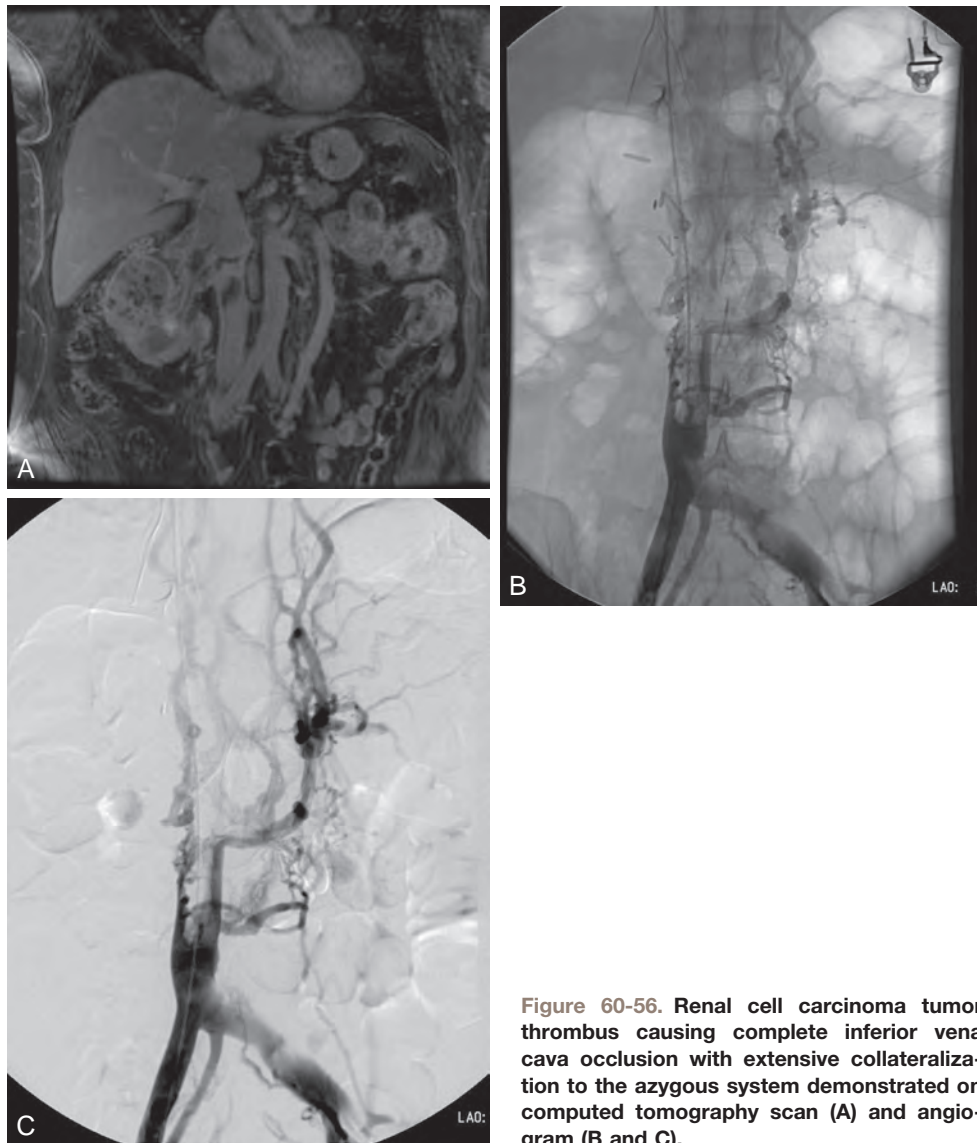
Renal cell carcinoma tumor thrombus causing complete inferior vena cava occlusion with extensive collateralization to the azygous system demonstrated on computed tomography scan (A) and angiogram (B and C).
